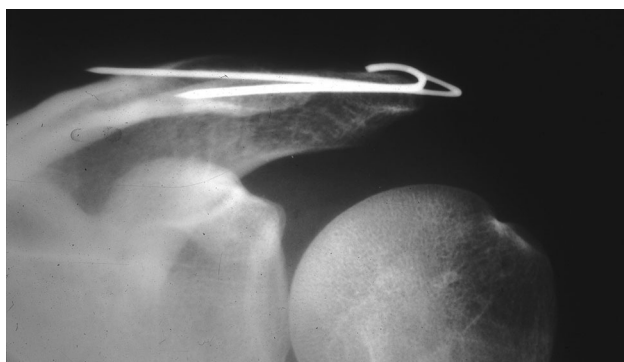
Postoperative X-ray control showing perfect reduction. The K wires are removed at 6 weeks
